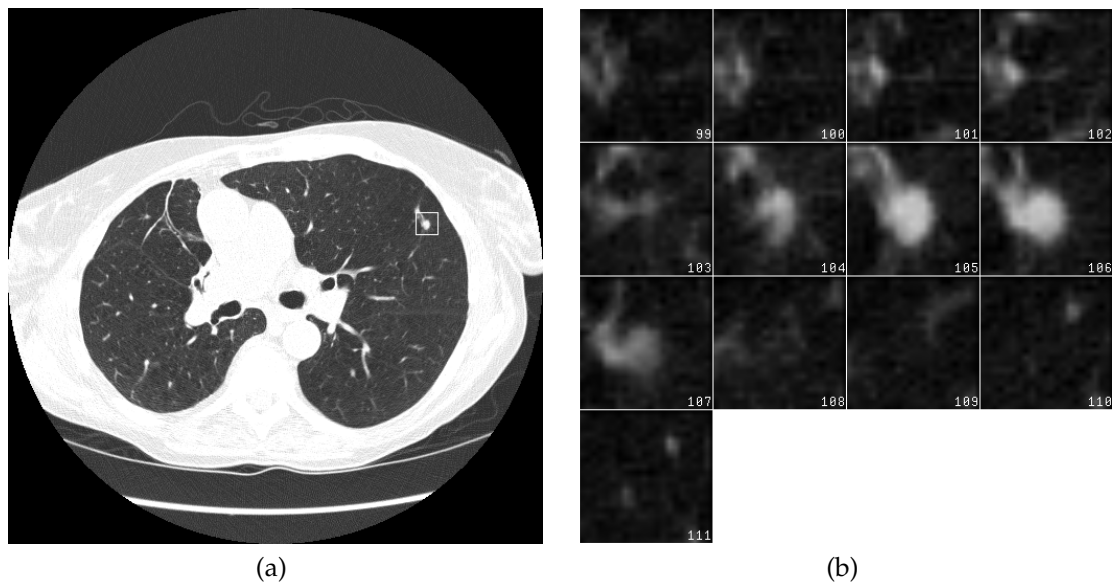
Small solid pulmonary nodule on a) single slice of a CT scan and b) several slices of a CT scan in a small region of interest
